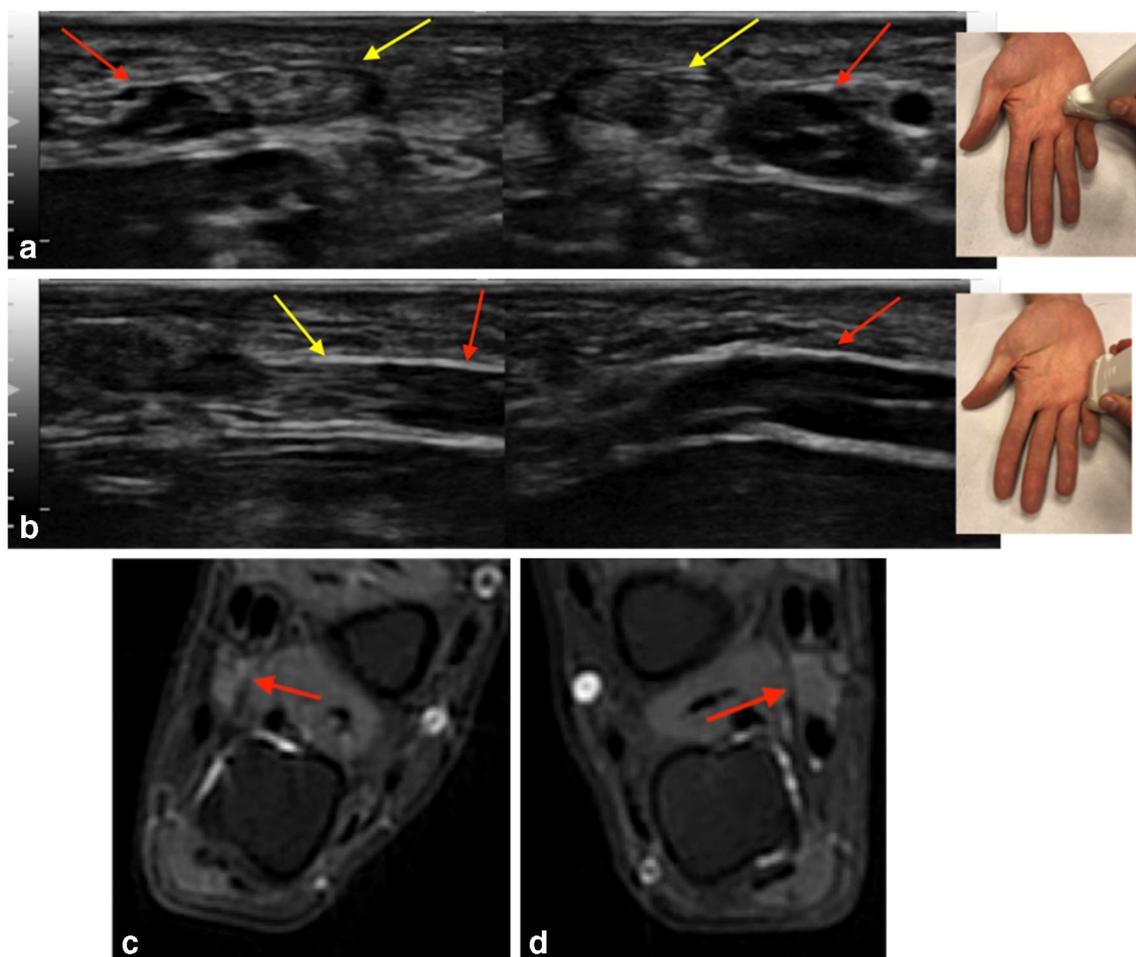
Decreased size of the fourth lumbrical muscle. A 16-year-old boy with camptodactyly. a Axial and b longitudinal ultrasound shows an important decrease in muscle size of the fourth lumbrical (*red arrows*) on the affected side (images on the left). Note the adjacent flexor tendon (*yellow arrows*). On the affected side, the superficial flexor tendon lies
